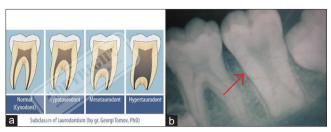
(a and b) Scheme of hypoplastic-hypomaturized Al development and bitewing radiograph of a clinical case
